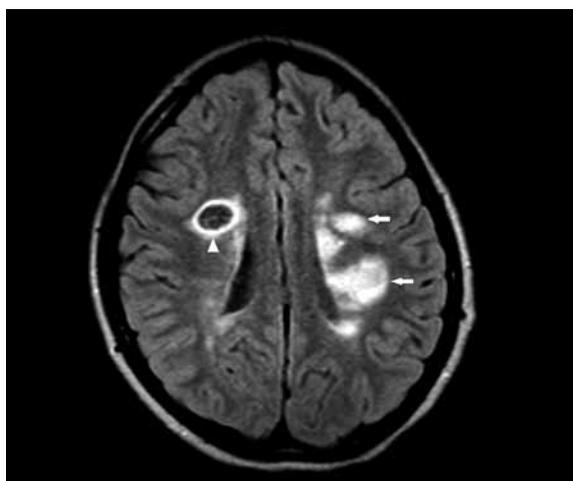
16-year-old girl, MRI brain scan, FLAIR FSE sequence image. Numerous, overlapping demyelinating foci in circumventricular white matter (arrows) with degenerative features in the right frontal lobe (arrow head).
